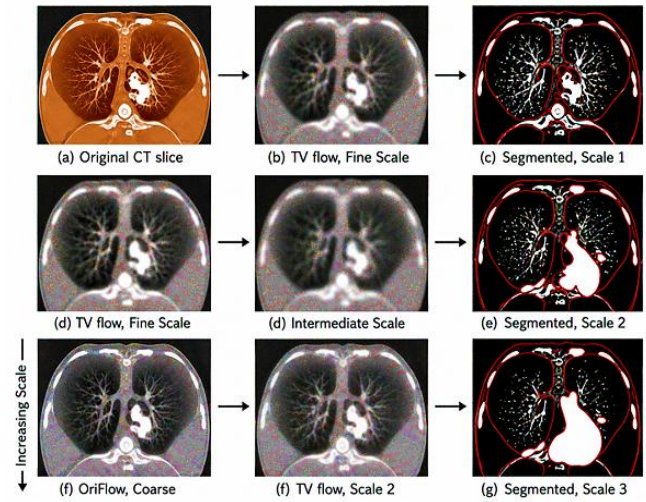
Multiscale segmentation of lung CT slice using TV flow. (a) Original CT; (b,d,f) TV flow evolution at increasing scales; (c,e,g) segmented regions; (h,j,l) contours of segmented objects.
